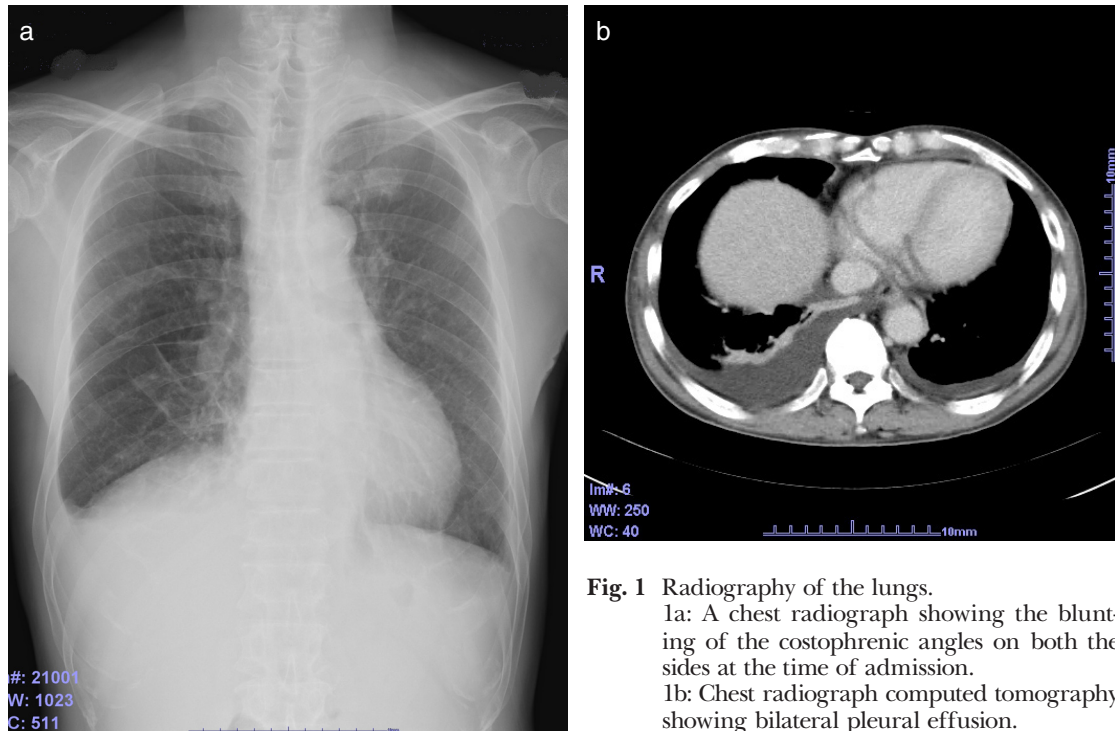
Radiography of the lungs.
